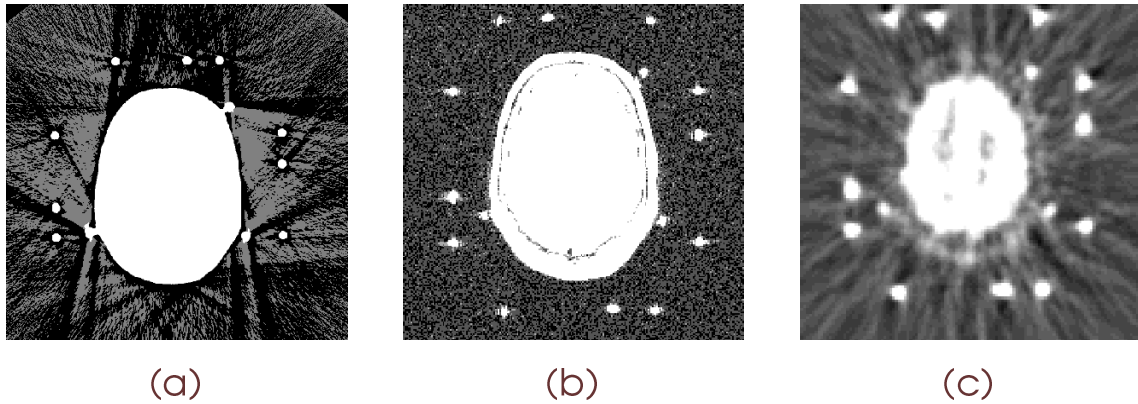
Original image volumes: (a) CT, (b) MR, and (c) PET. The stereotactic frame (bright circular spots towards the edge of the image) and fiducial markers (three bright spots near the head) are clearly visible in all three modalities.
